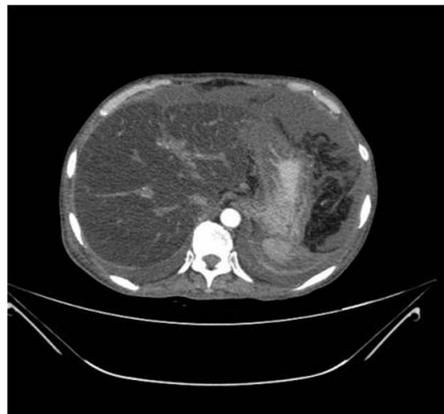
postoperative CT showing severe hepatic steatosis, Ascites and complete atrophy of spleen
